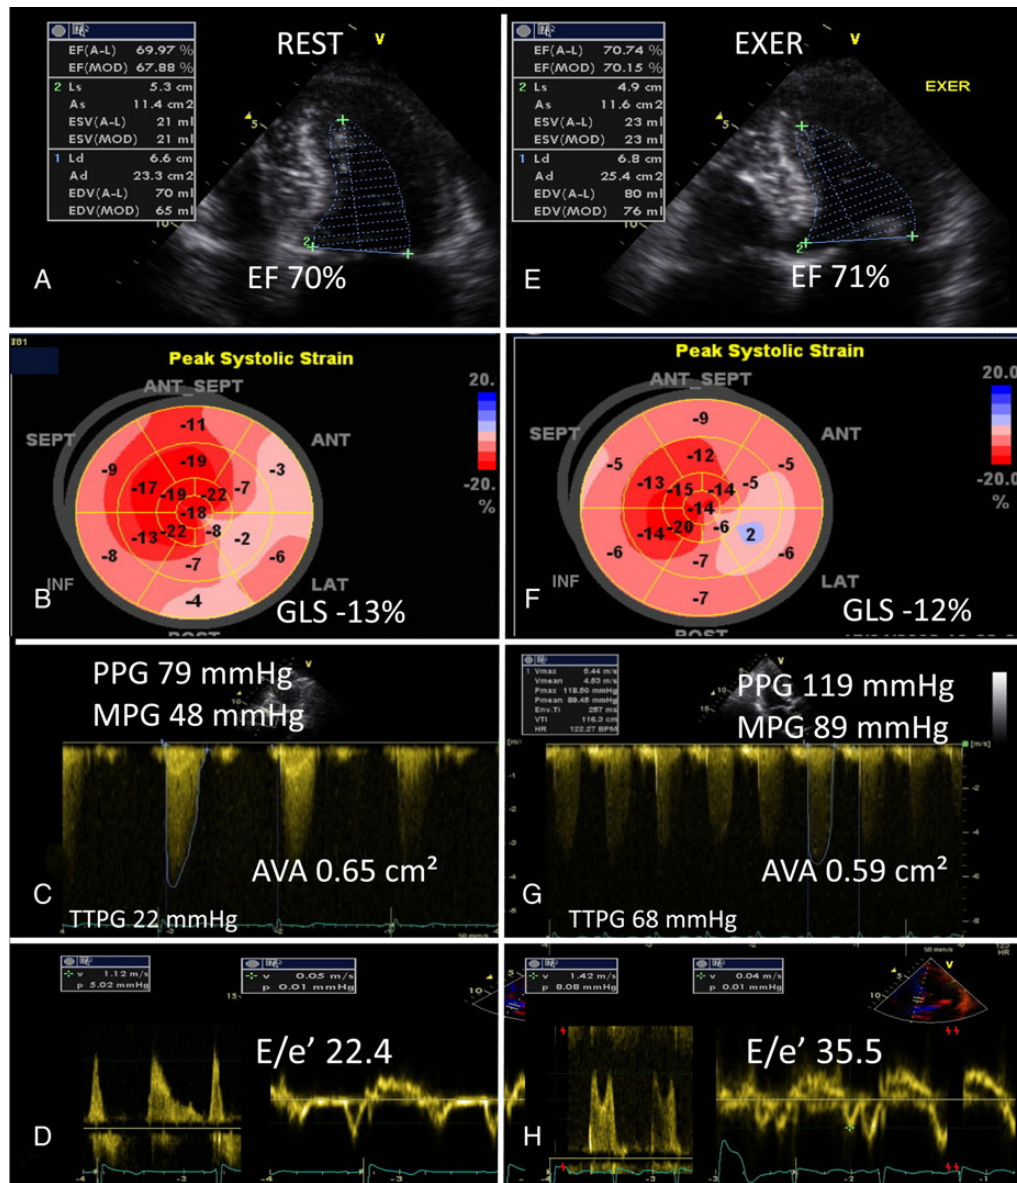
Asymptomatic patient with severe aortic stenosis and significant increase in transaortic pressure gradient, systolic PAP (transtricuspid pressure gradient [TTPG]), and E/e' during exercise echocardiography. Note that the left ventricular EF and the global longitudinal strain (GLS) remained unchanged, indicating the absence of contractile reserve. Also during test, blood pressure increased by >20 mmHg and neither symptoms nor significant ST segment changes were observed. (A–D) Rest evaluation; (E–H) exercise echocardiography results. AVA, aortic valve area; Exer, exercise; MPG, mean pressure gradient; PPG, peak pressure gradient.
